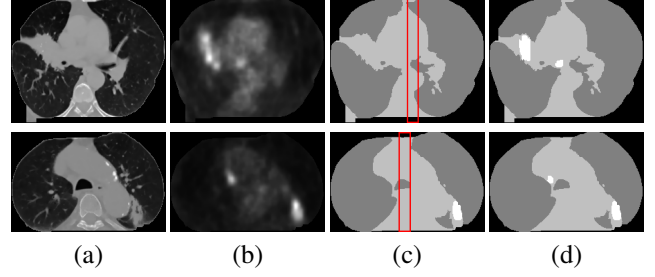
Example detection outputs using our proposed method, with each row showing one example. (a) Transaxial CT image slices (showing the thorax after preprocessing). (b) Co-registered PET image slices. (c) The initial labeling outputs, with dark gray for category L, light gray for category O and white for category R, and the localized bounding boxes for calculating V_M highlighted in red. (d) The final detection outputs, with abnormalities in white.
